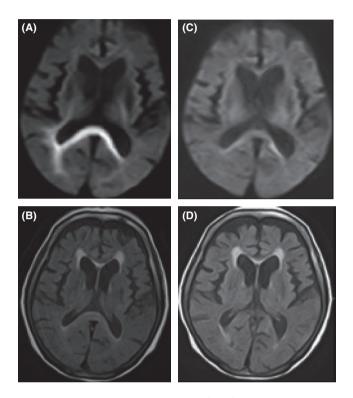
Diffusion-weighted image (DWI) and fluid-attenuated inversion recovery (FLAIR) showed high signal intensity in the bilateral corpus callosum ampulla (DWI: A, FLAIR: B). Lesions in the bilateral corpus callosum ampulla disappeared on 25 days after cessation of MNZ (DWI: C, FLAIR: D)
